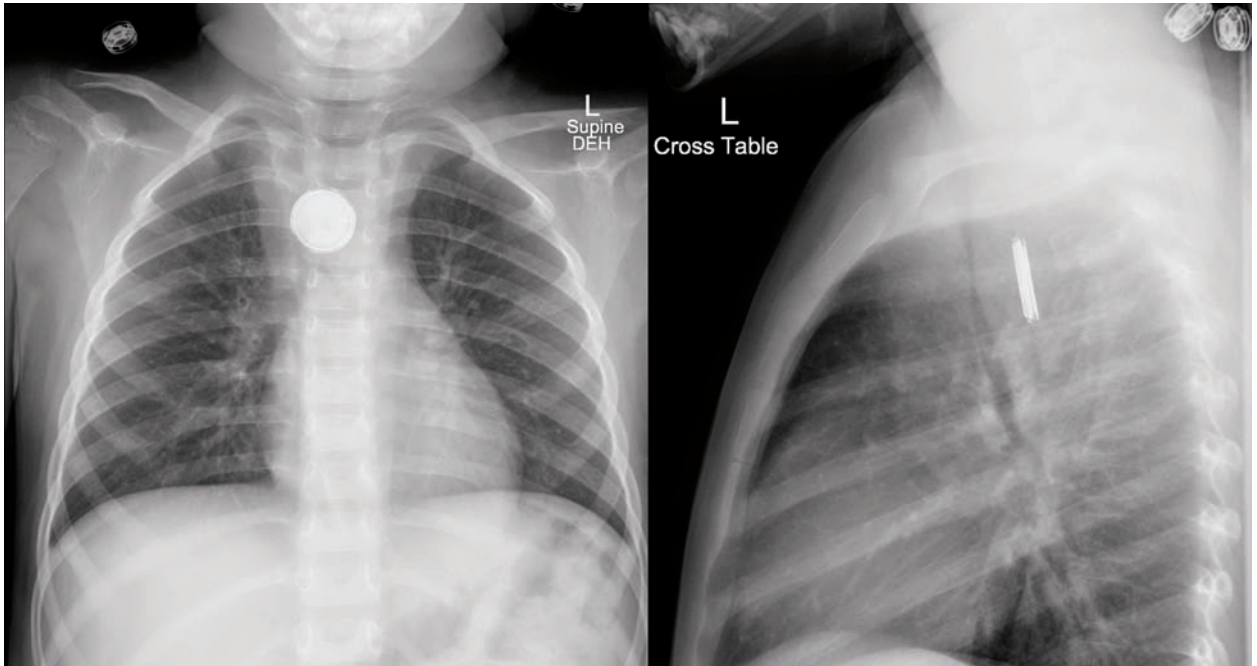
Anteroposterior/lateral chest x-ray reveals a radiopaque foreign body within the area of the esophagus, concerning for foreign body ingestion.
